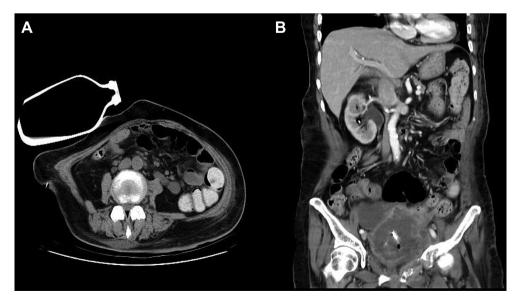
Abdominal computed tomography after supportive treatment. (A) A 500 mL bottle and tight sponge usage as direct compression is noted. (B) No further bleeding or hematoma is noted in the retroperitoneum after percutaneous nephrostomy catheter removal.
